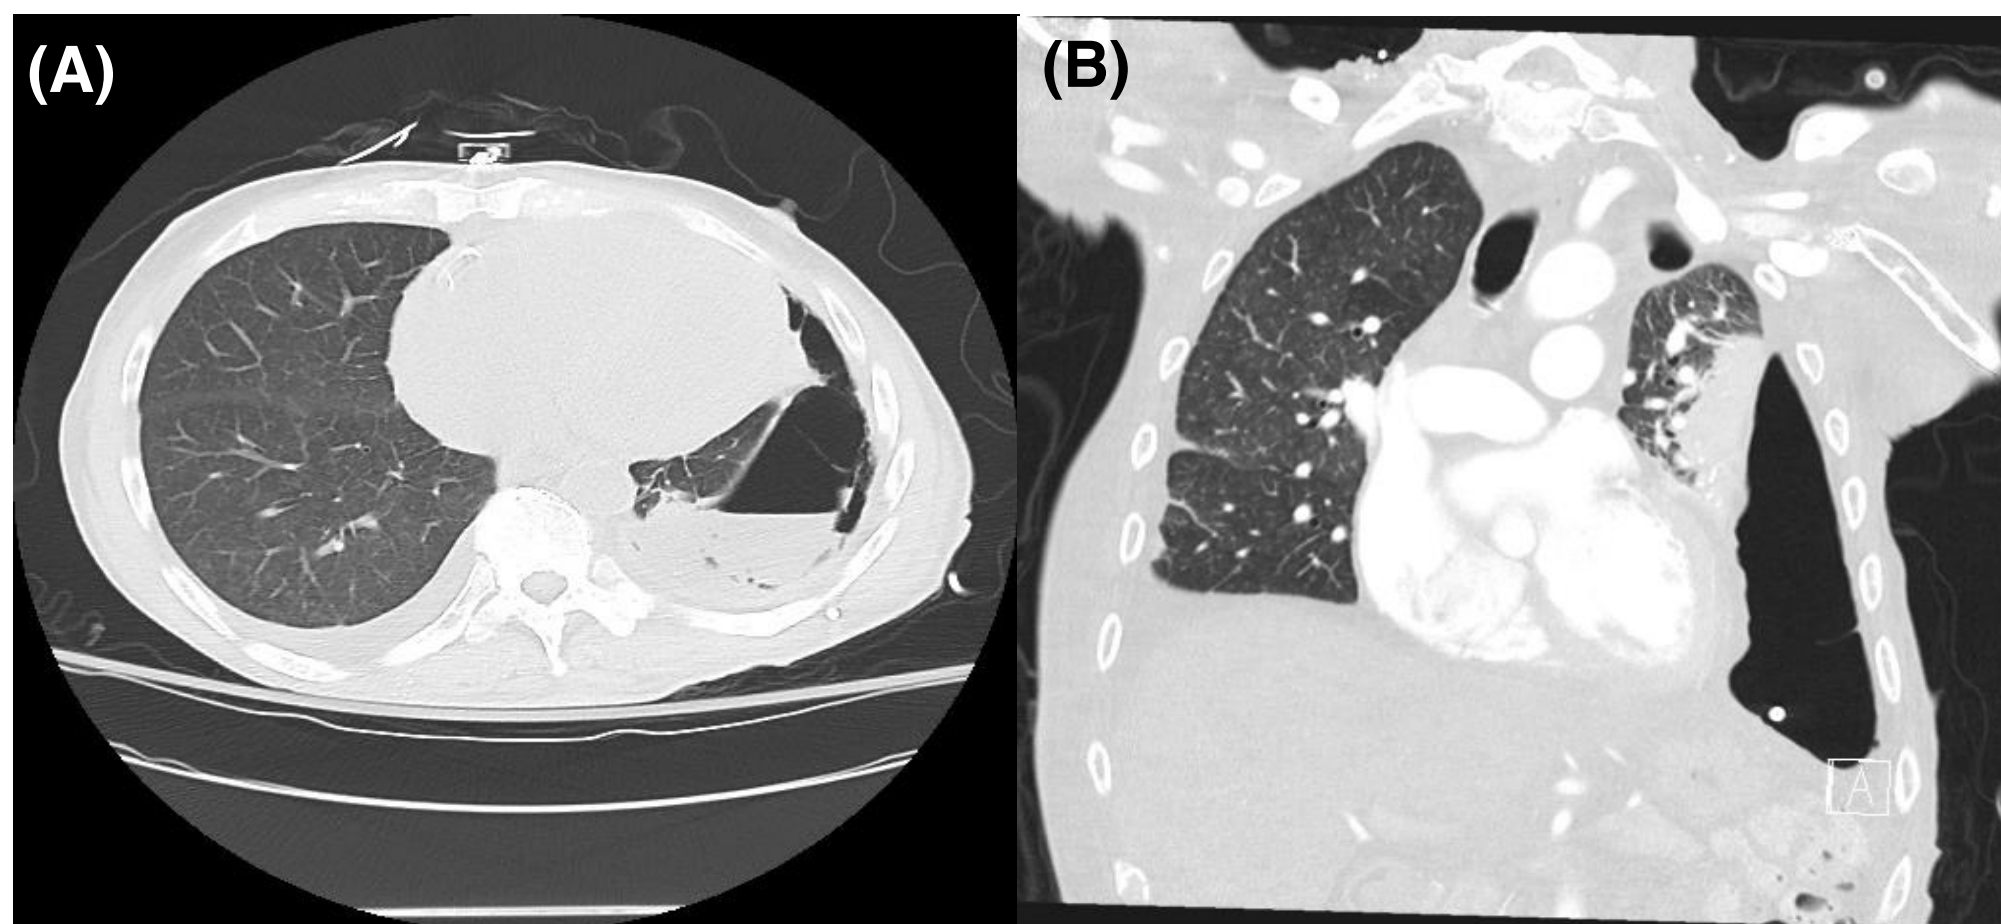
(A) Transverse and (B) coronal CT of the chest demonstrating loculated left sided pleural effusion with indwelling intrapleural catheter and near complete collapse of left lung.
